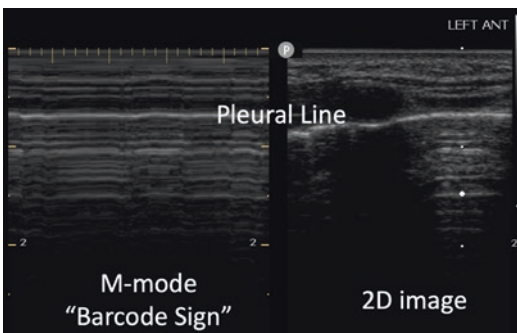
Linear probe M-mode ultrasound image (left) demonstrating the “barcode sign,” which is suggestive of a pneumothorax located in the area under the ultrasound probe. The corresponding 2D ultrasound image is shown on the right side
